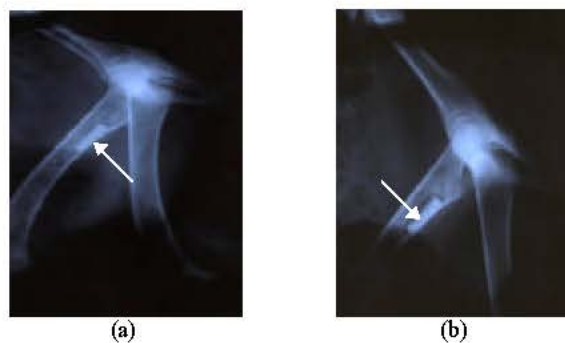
Radiographs of the left femoral bone taken a) at week 8 post-implantation demonstrates the CPC implant is still maintain its radiodensity with distinct margins, b) at week 12 post-implantation demonstrates the margins show an area of radiolucency indicating some resorption occurred
